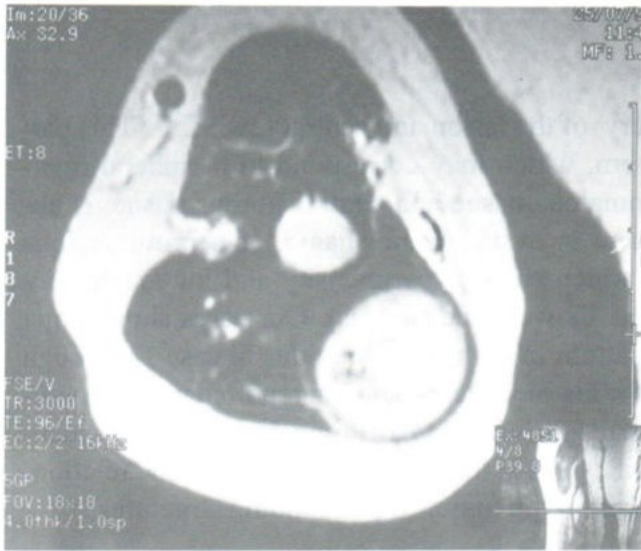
C : T2-weighted axial MR image discloses peripheral hypersignal area whereas the central area shows mainly hyposignal intensity.
